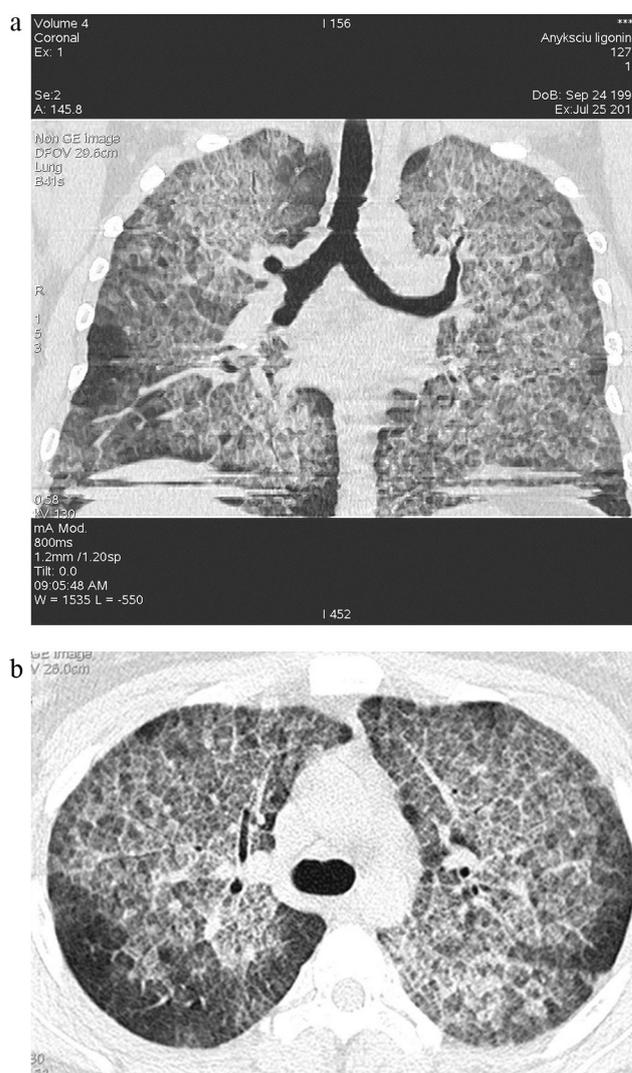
(a and b) CT scan (axial and coronal reformatted image, lung window) demonstrating widespread ground-glass opacity, thickened interlobular septa and intralobular lines (crazy-paving pattern).
